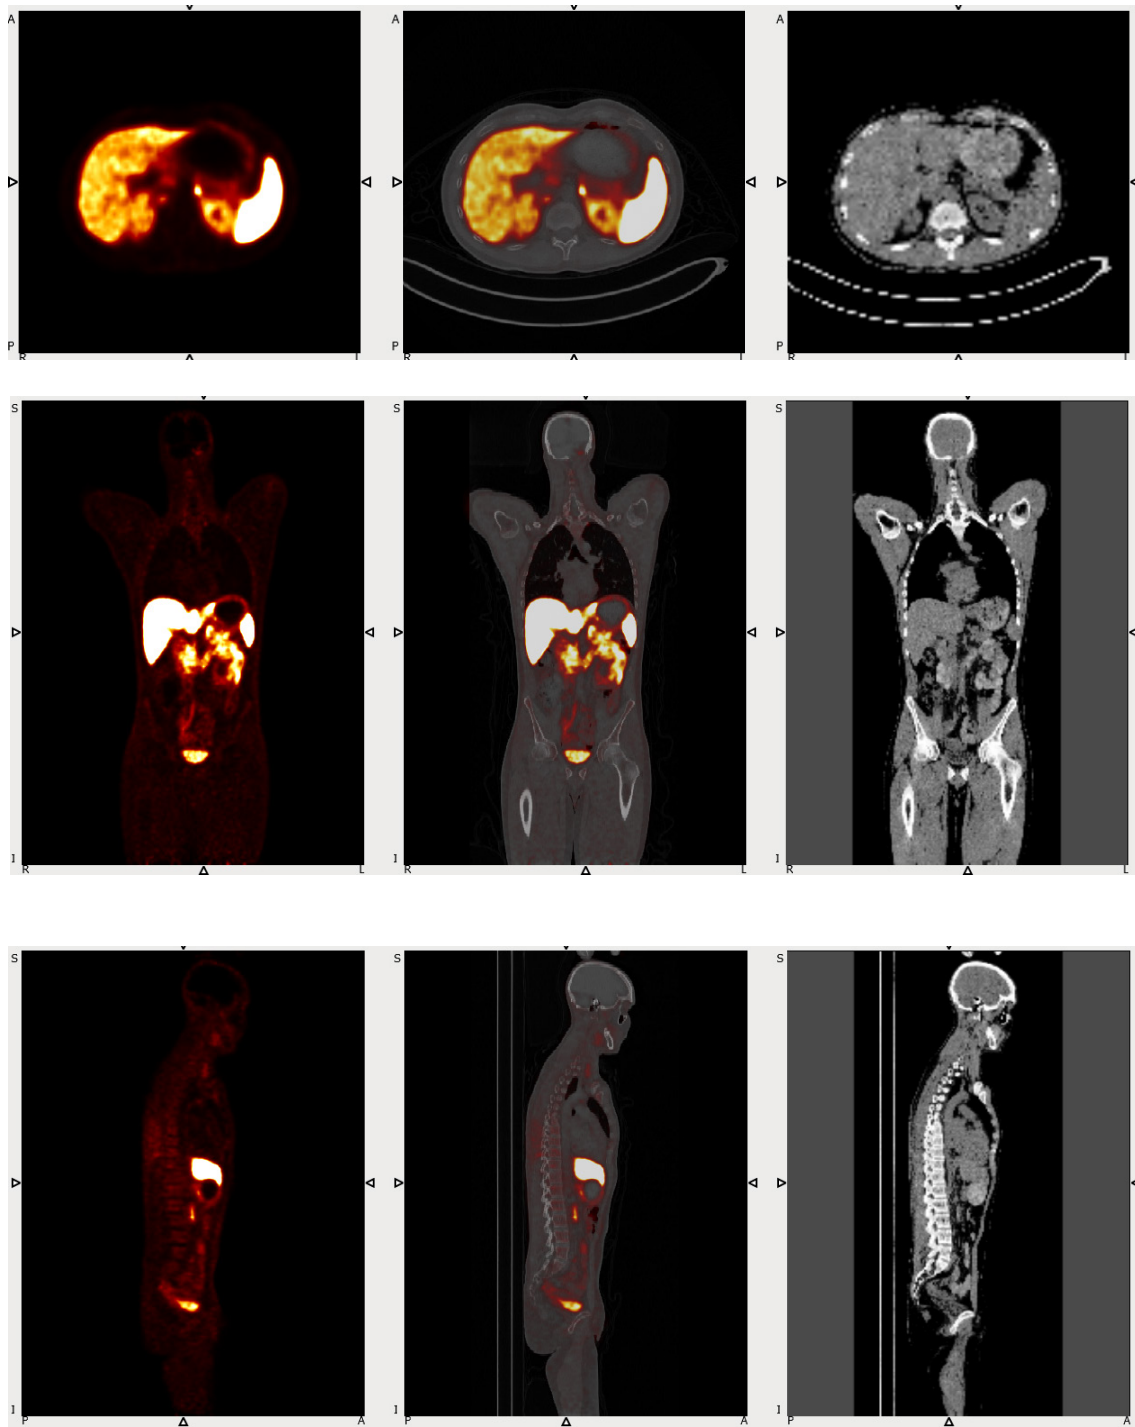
19:  $PET_0$  (first column),  $PET_0/CT$  (second column) and generated attenuation map (third column) according to Appendix J. The first row is axial, the second row is coronal, and the third row is sagittal views for patient 20, where  $PRC_5$  was suffered from artefacts.
